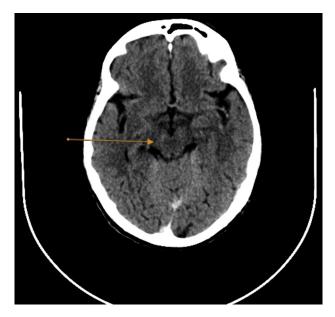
CT axial image of brain at the level of midbrain (arrow) showing hypodensity consistent with acute brainstem infarction. CT, computed tomography.
